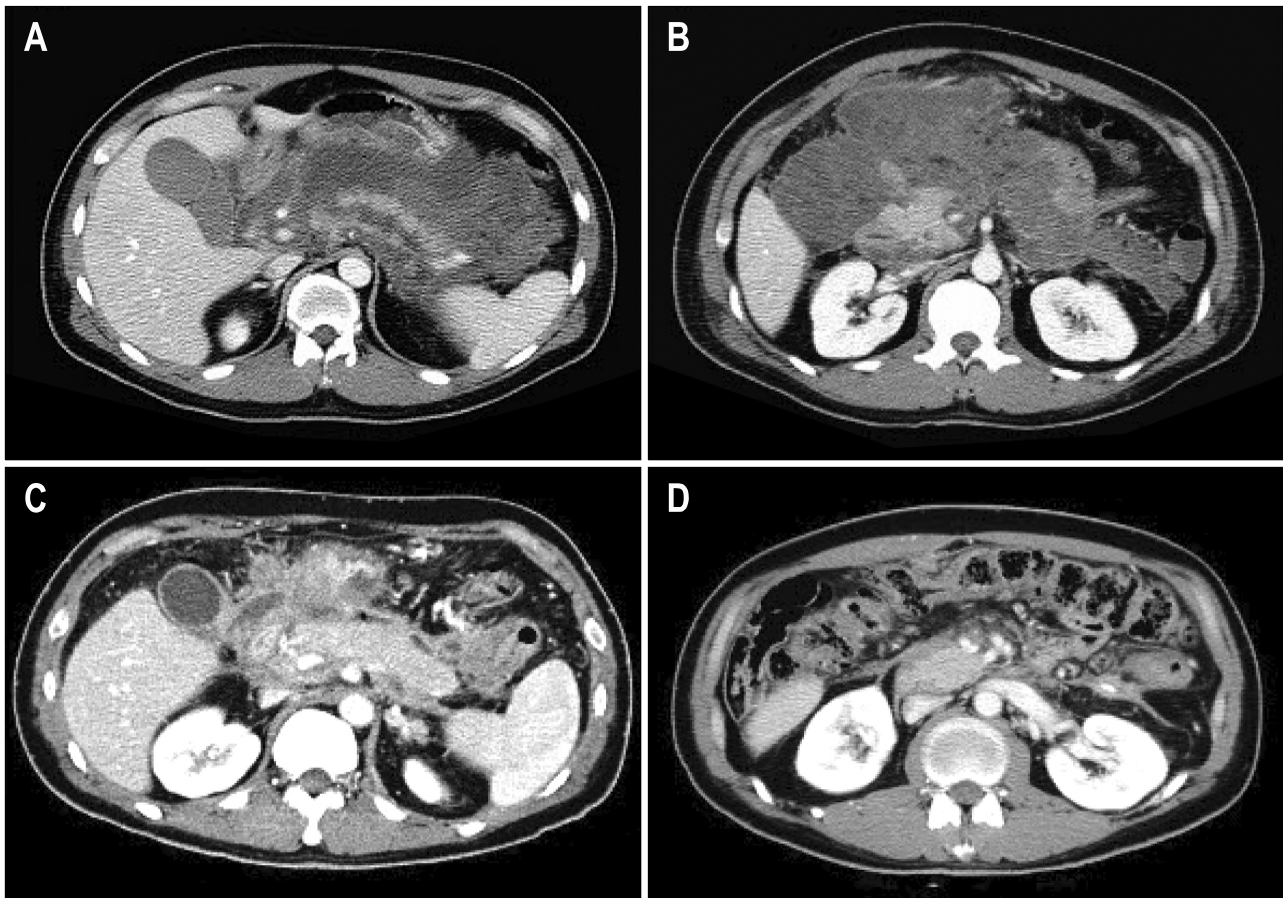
(A, B) CT images showing peripancreatic necrosis; this lesion extended to the retroperitoneal and peritoneal cavity as far as the left pararenal space. (C, D) After multitransgastric endoscopic necrosectomy, a follow-up CT also showed the near resolution of the infected peripancreatic necrosis. The time interval between the images in panels A and B and those in panels C and D was 49 days.
